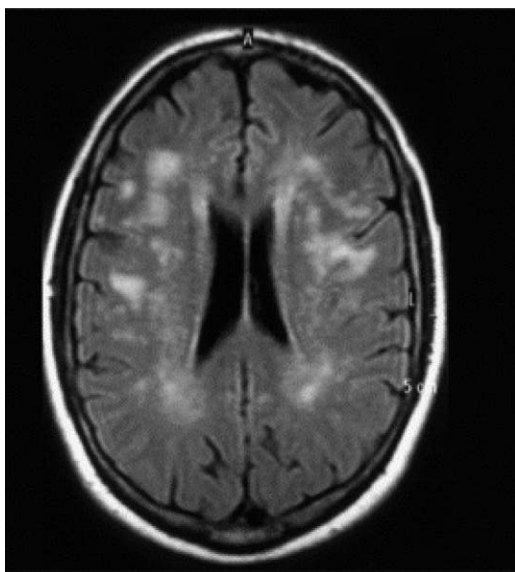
T2-weighted axial MRI. Zones of hypersignal in the periventricular and parietal subcortical white matter.
